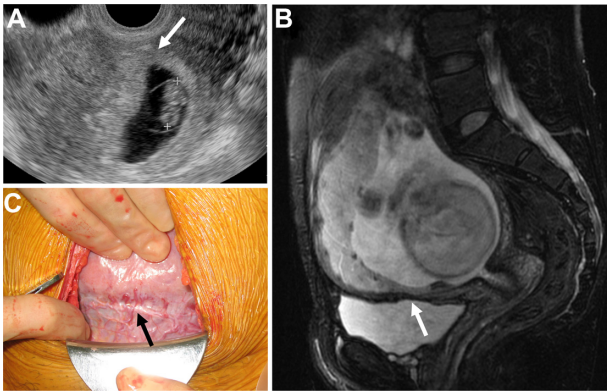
Findings in a subsequent pregnancy after successful conservative management of cesarean scar pregnancy. (A) Transvaginal ultrasonography showing normal fetal growth with cardiac activity and low-lying placenta attached to the anterior wall of the uterus at 8 weeks of gestation. Lower segment of placenta attached to the cesarean section scar (arrow). (B) Sagittal magnetic resonance imaging showing attachment of the lower part of the placenta to the previous cesarean section scar (arrow) at 19 weeks of gestation. (C) Uterine scar showing slight decompression (arrow) at emergency cesarean section performed at 36 weeks and 5 days of gestation.
